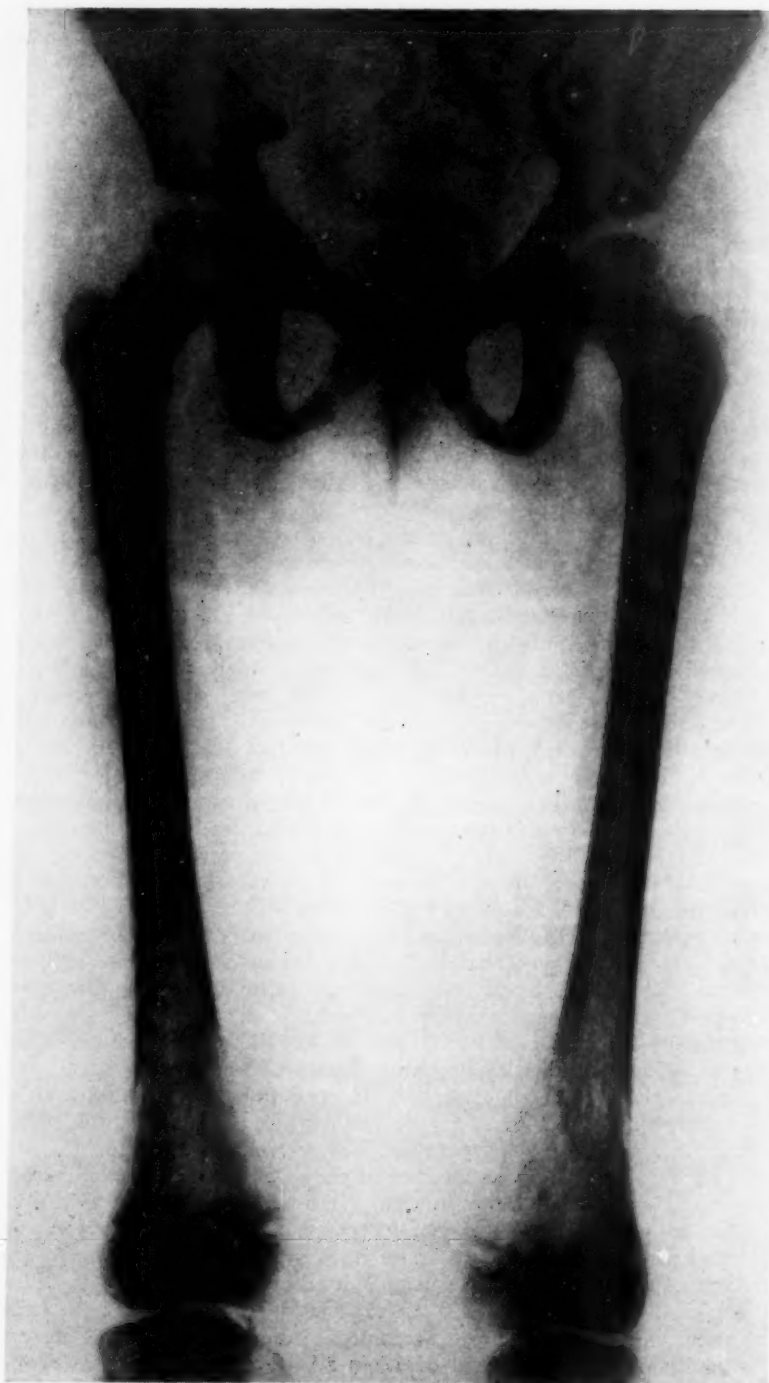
Roentgen-ray demonstrates marked rarefaction of bones, particularly marked in the lower end of both femora. At autopsy the cortex of the rarefied area in the left femur was of egg shell thinness.
